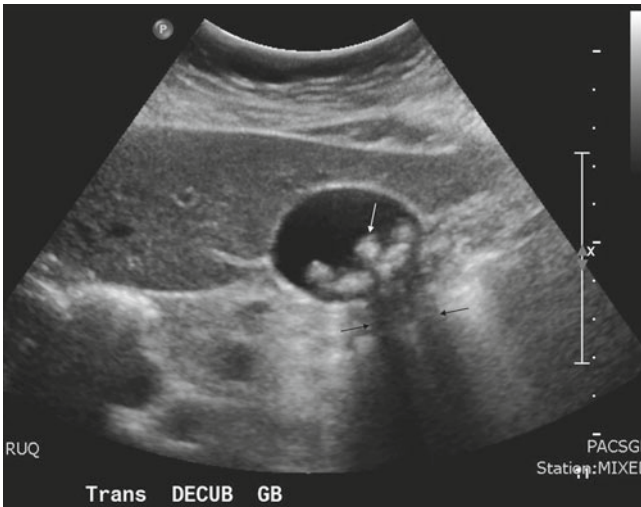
A 65-year-old woman with RUQ abdominal pain and tenderness. Right upper quadrant decubitus ultrasound image shows multiple echogenic foci with acoustic shadowing (*black arrows*) within the gallbladder; these are gallstones (*white arrow*). Diagnosis: Gallstones
